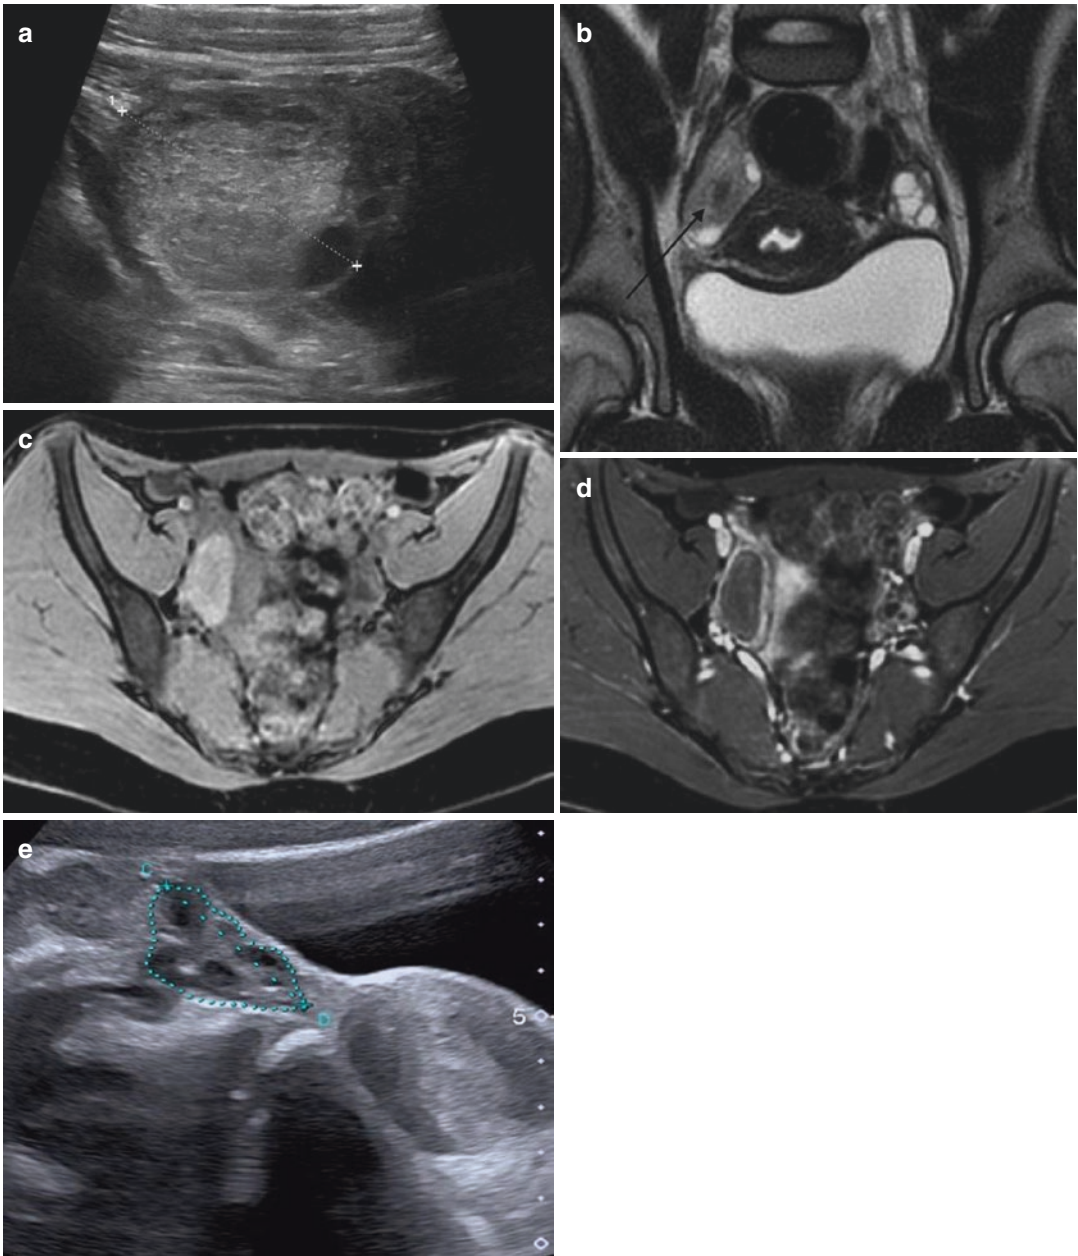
Functional hemorrhagic cyst in a 14 year-old girl. (a) US Axial view: Hyperechoic cyst within the ovary. The echogenicity raises a doubt about a possible endometrioma justifying the realization of a MRI. (b) MR imaging: Coronal T2-Weighted sequence. Cyst with homogeneous high T2-W intensity (arrow). (c) MR
